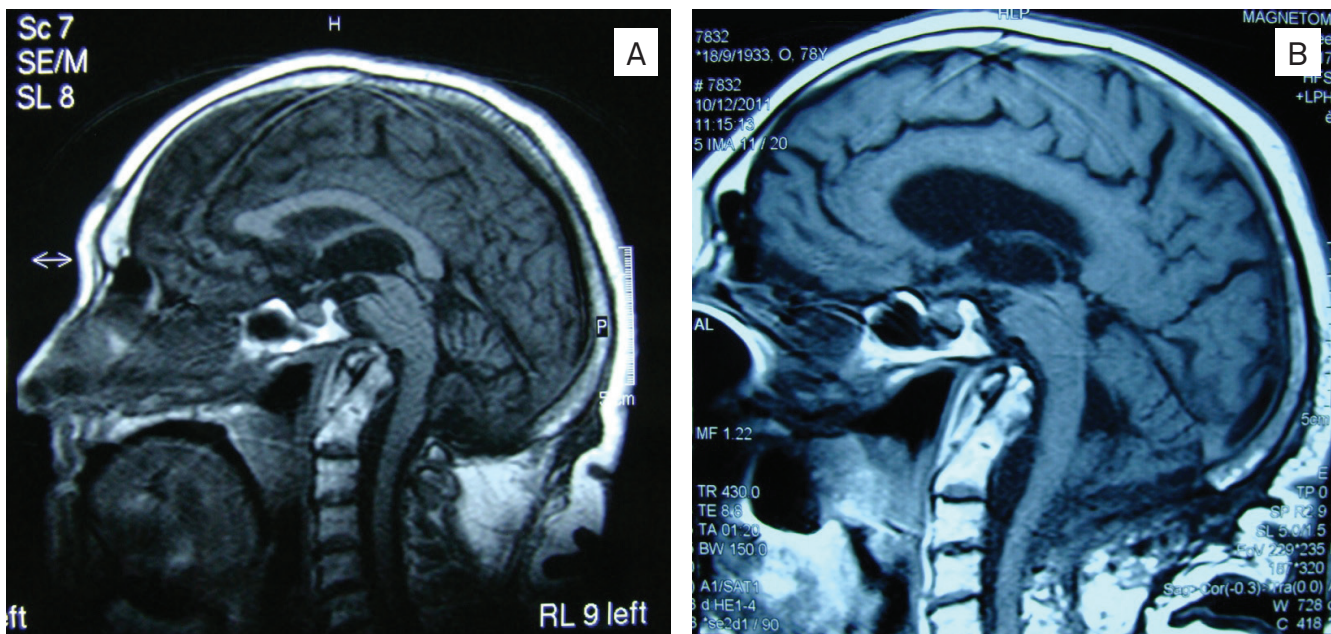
(A) Preoperative MRI showing tonsillar herniation and anterior compression of the brainstem. (B) Postoperative MRI depicting upward migration of hindbrain and no compression of the brainstem.
